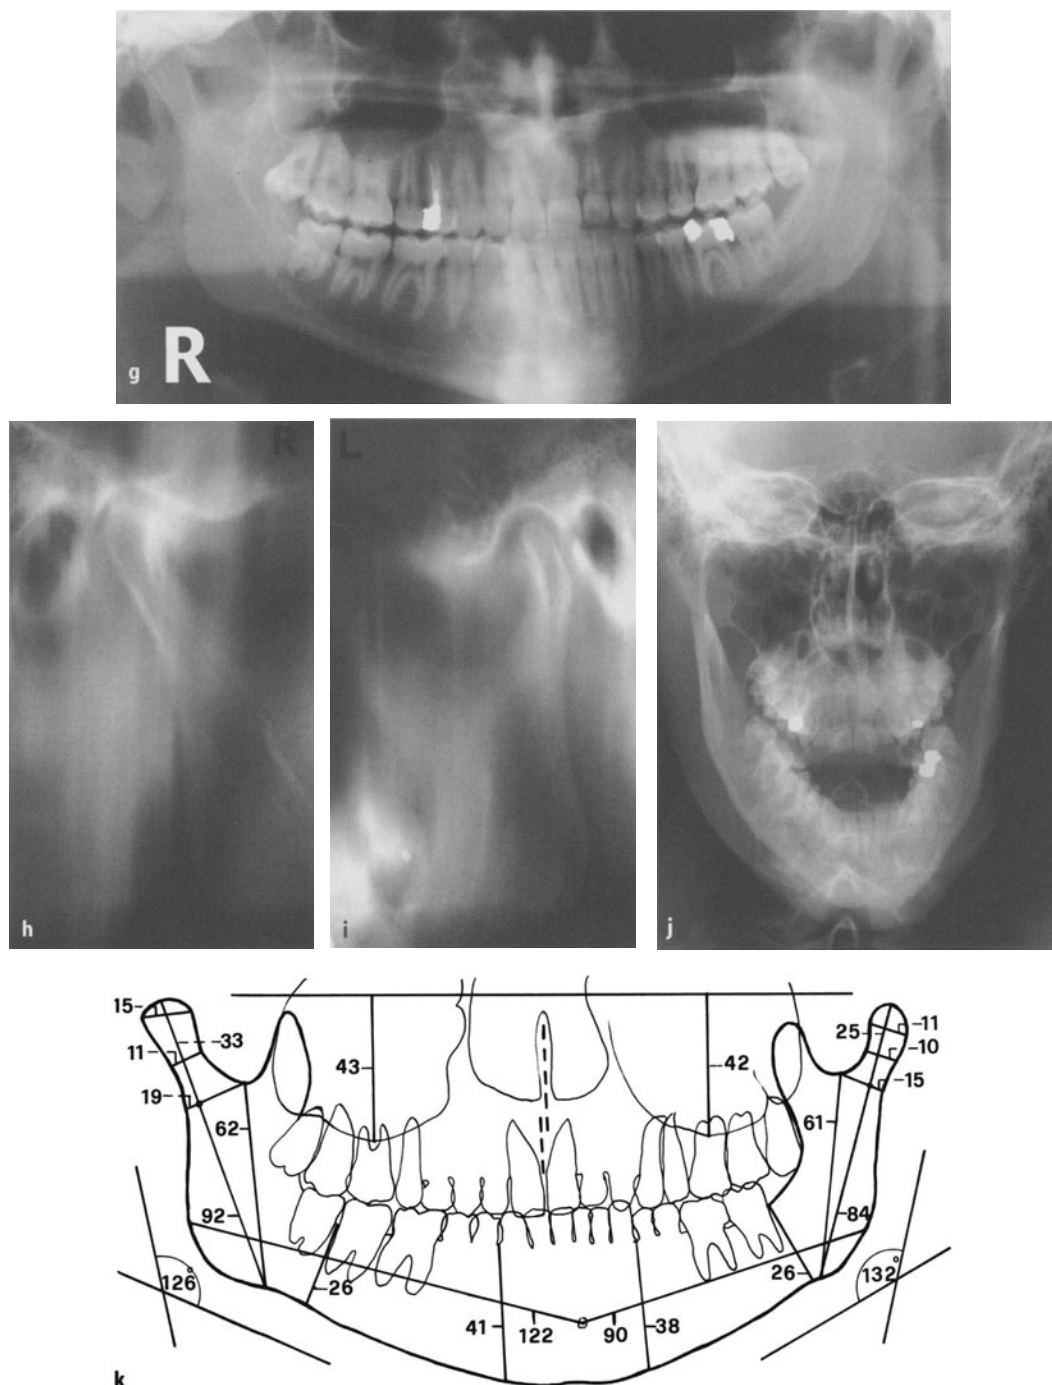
Unilateral H.E., medium-slender type. g The panoramic view shows the pronounced deviation of the chin, but the neck-condyle situation is not very typical of a right side H.E. h, i The tomograms of the TMJ including ramus show the clear picture of an unilateral H.E. j The mandible in p.a. projection in the open mouth position leaves no doubt about a right side H.E. k The tracing of the panoramic radiograph and its measurements prove clearly the diagnosis of an unilateral H.E.
